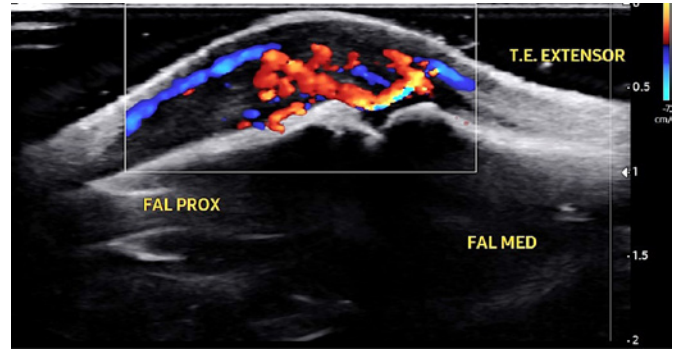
Color Doppler showing intense vascularization of the tendon, both centrally and peripherally.
